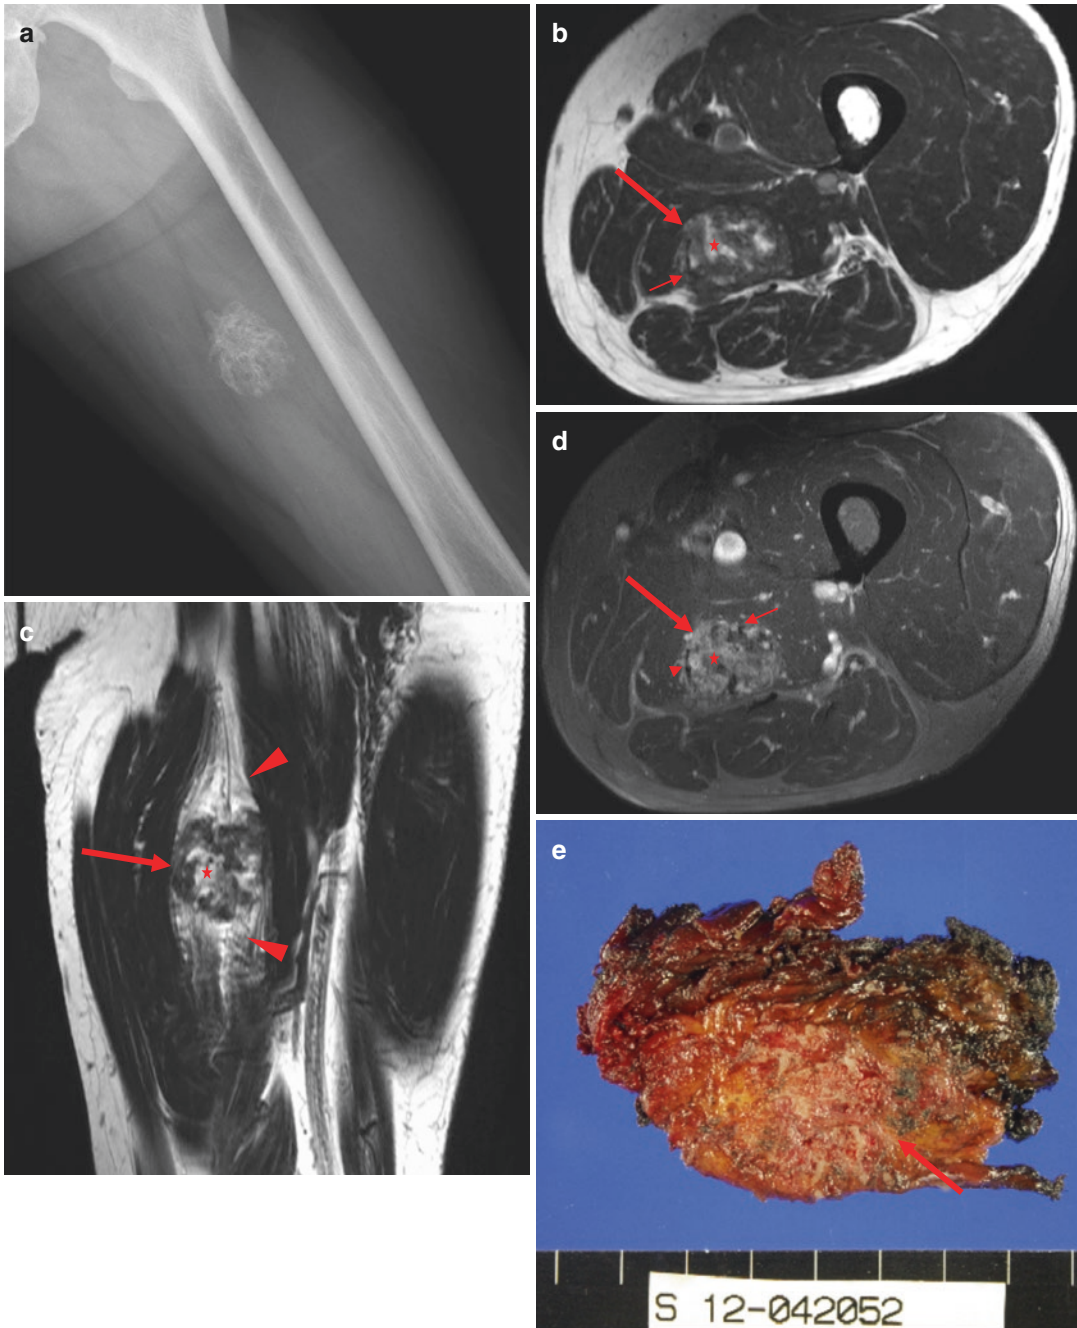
Ossifying intramuscular angioma. Radiograph (a) of the distal thigh shows an ossified mass with Swiss cheese appearance. Axial T1WI (b) reveals a heterogeneously hyperintense soft tissue mass (arrow) relative to muscle in the adductor magnus muscle. Prominent cranio-caudal perilesional fat overgrowth (arrowheads) is noted on coronal T2WI (c). Axial postcontrast FS T1WI (d) reveals
